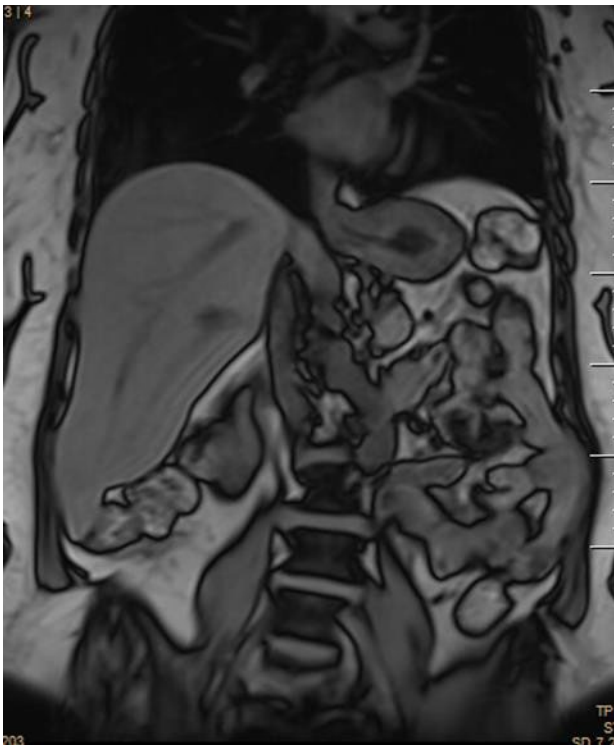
Abdominal MRI. No evidence of vena cava thrombosis during follow-up
